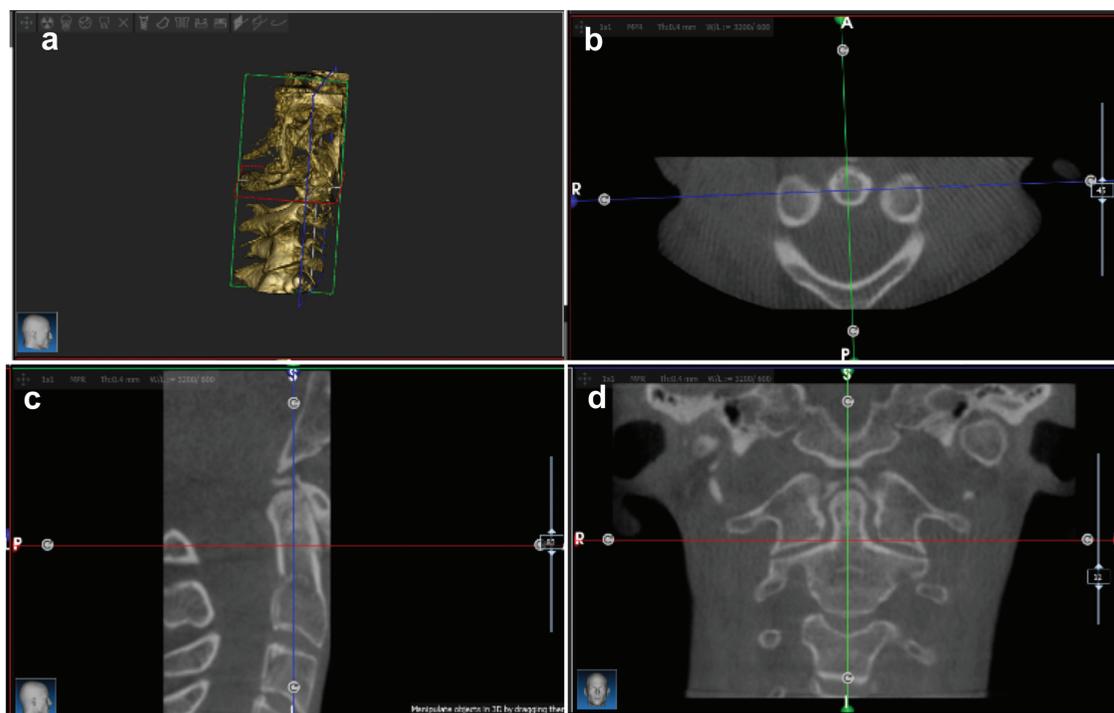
Orientation of a slice of a cone beam computed tomography (CBCT) image. (a) 3D representation of the image cropped to focus on the cervical vertebrae of interest. (b) Axial view of the image with the left and right regions of CV1 and the dens of CV2. (c) Sagittal view of the image. (d) Coronal view of the image, as used for measurements.
